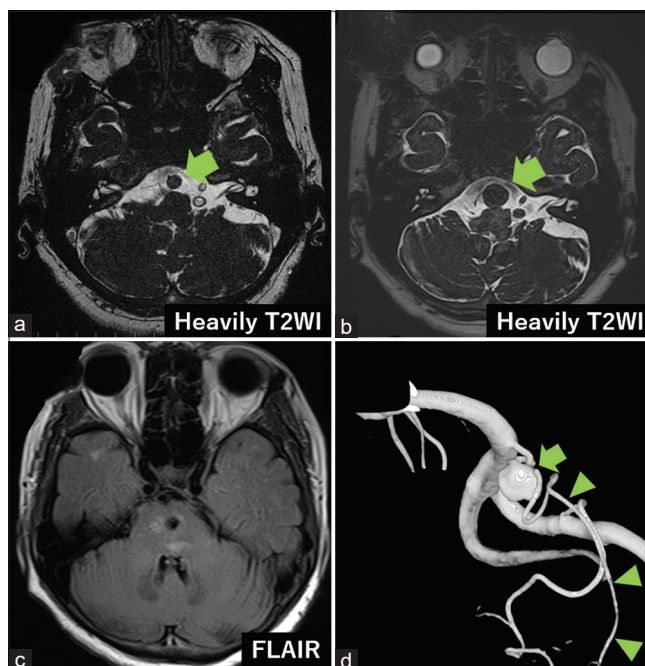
Imaging findings before and after the treatment. (a) Magnetic resonance (MR) image showing the aneurysm (9 mm, arrow) anterior to the brainstem when the patient was 68 years old, (b) MR image showing enlarged aneurysm (14 mm) when the patient was 70 years old (arrow), (c) MR image showing brainstem mass effect due to the aneurysm, (d) three-dimensional digital subtraction angiography showing a right proximal anterior inferior cerebellar artery (AICA) aneurysm (arrow) and the distal AICA (arrowheads) appearing from the aneurysm body.
